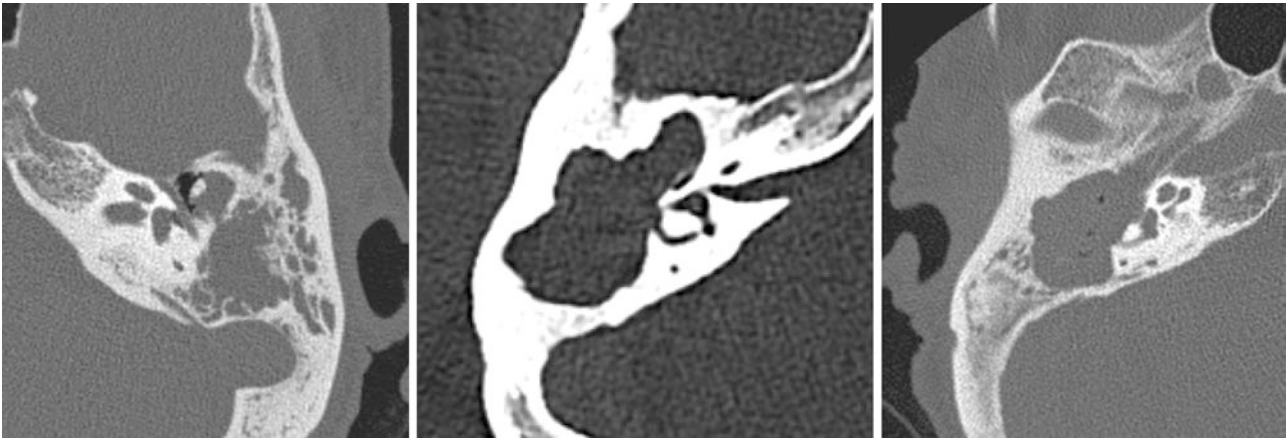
Three computed tomography scans of the temporal bone from three different patients with cholesteatoma showing erosion of the middle ear and mastoid. The first image shows a bony erosion restricted to the scutum and mastoid antrum. The second image shows intense
